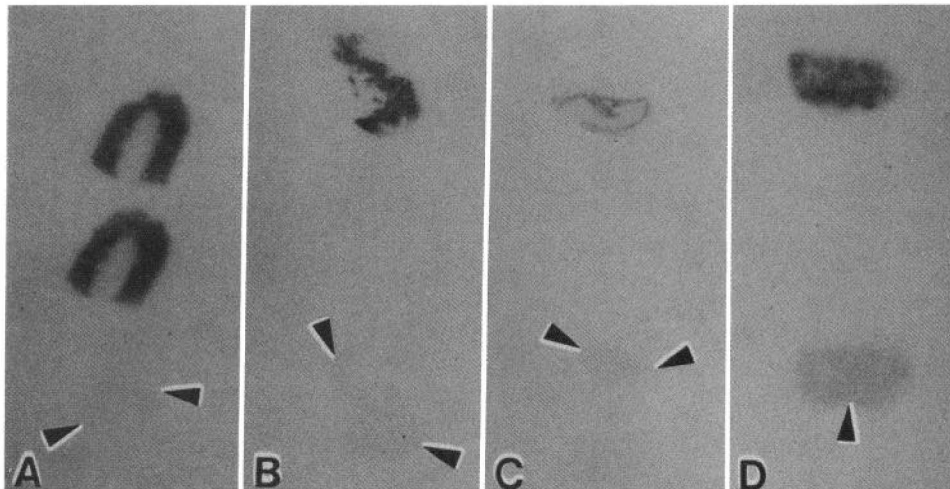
Specific binding of ^{125}I -enterotoxin to kidney cortex (A), small intestine (B), and colonic mucosa (C) and testes (D) revealed by *in vitro* autoradiography. Data are representative experiments of at least 6 different experiments with frozen sections from these tissues (see EXPERIMENTAL PROCEDURES for details). Exposure of X-ray film varied from 4 to 16 h and data are intended to demonstrate tissue localization and not receptor density. Sections of brain (cortex) and skeletal muscle have consistently shown no specific binding of ^{125}I -enterotoxin (data not shown).
